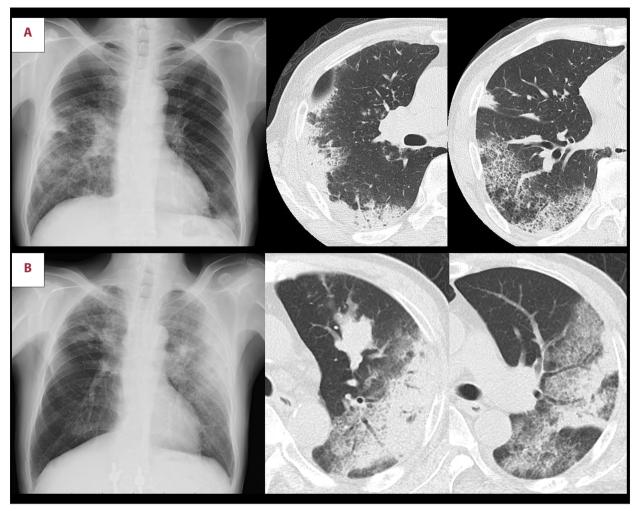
X-rays and CT when interstitial pneumonia appeared. (A) Interstitial pneumonia after 3 cycles of nivolumab treatment. (B) Recurrence of interstitial pneumonia after re-challenge with nivolumab.
